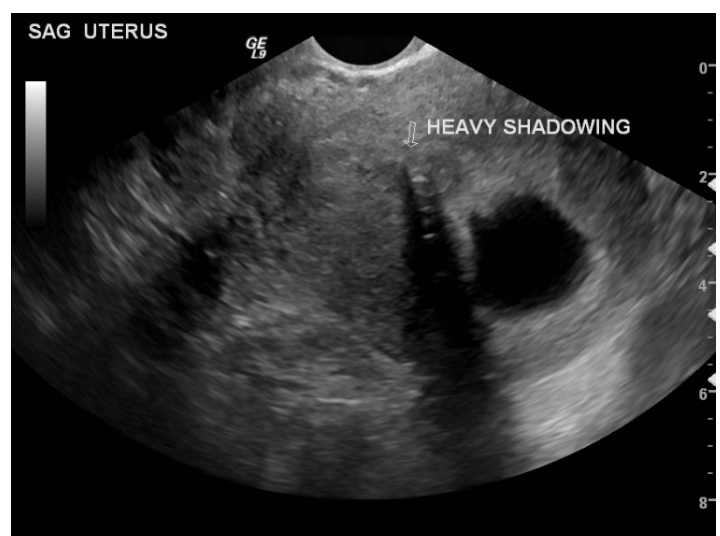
Transvaginal ultrasound image showing a foreign object within the uterus (arrow) next to a gestational sac.
